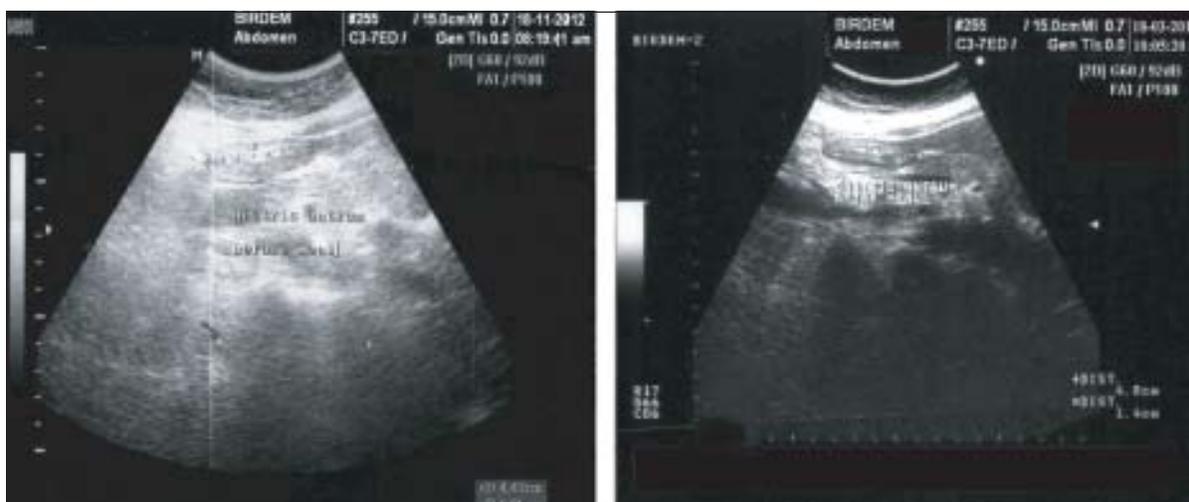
Sonographic Image of gastric antrum of type 2 diabetics before meal 90 minutes after breakfast
